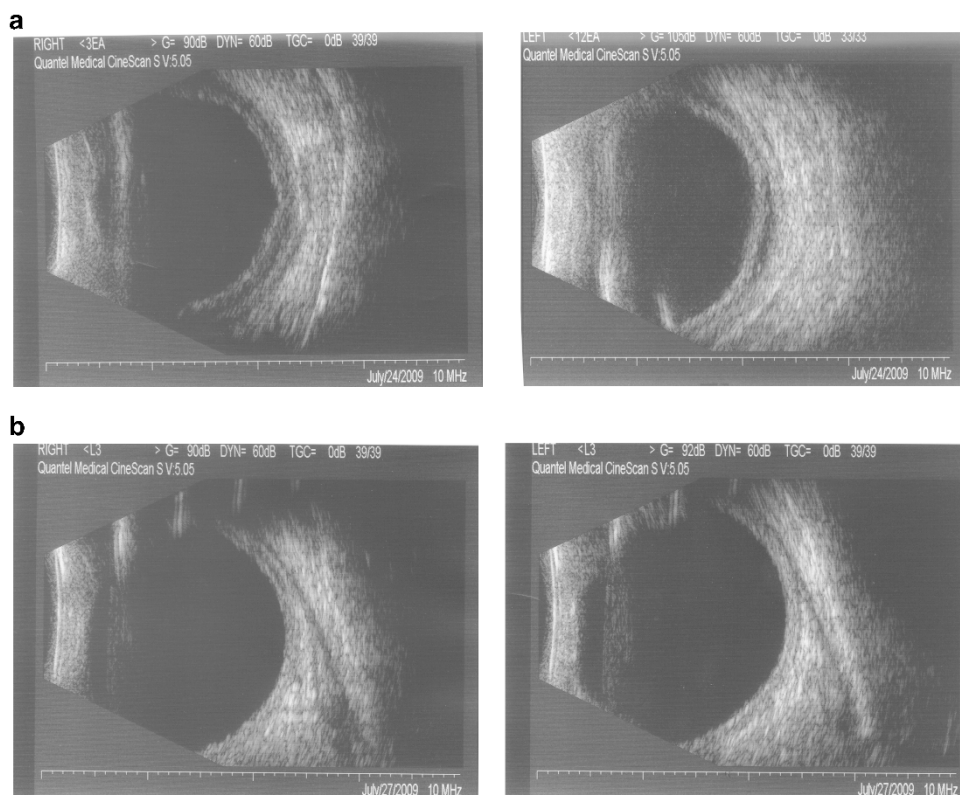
(a) B scan ultrasound at presentation showed bilateral peripheral choroidal thickening with ciliochoroidal detachment, present almost 360°. The low to medium reflectivity is suggestive of choroidal effusions. (b) Almost complete resolution of bilateral choroidal effusions a few days after discontinuation of isoniazid.
